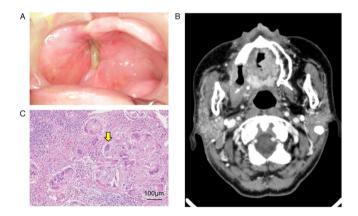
(A) The ulcer on the right upper gingival disappeared and the induration improved. (B) No recurrence was found on contrast-enhanced computed tomography of the maxillary gingival lesion. (C) Metastatic lymph nodes dissected from the neck show tumor coagulative necrosis and foreign body giant cells (arrow).
